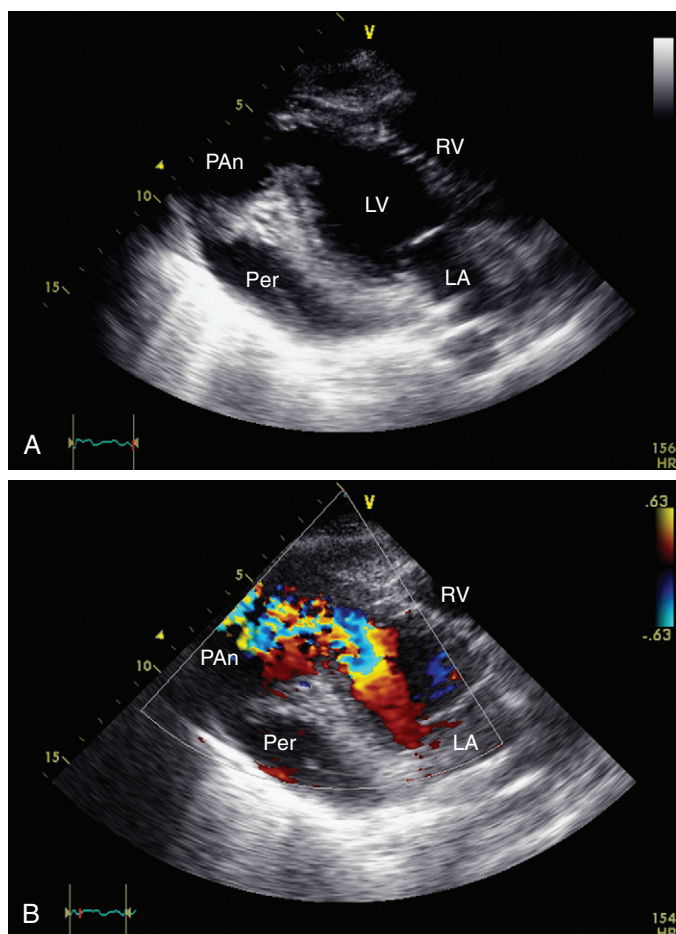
A, Apical long-axis view, slightly off-axis, shows abrupt discontinuity of the distal inferolateral wall, resulting in a communication between the LV and a large cavity that appears to be a pseudoaneurysm. The “aneurysmal” cavity was pulsatile during real-time imaging. B, On color Doppler, flow is seen from the LV toward the pseudoaneurysmal cavity (arrow). LA, left atrium; LV, left ventricle; PAn, pseudoaneurysm; Per, pericardial effusion; RV, right ventricle.
